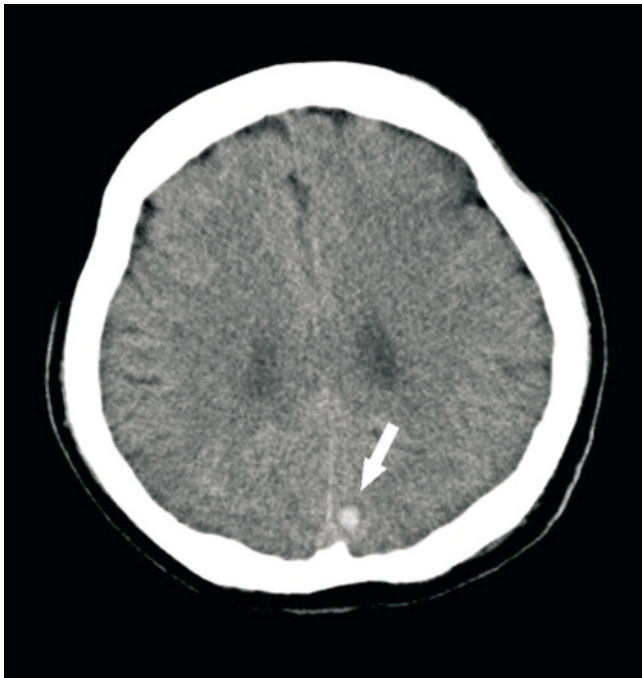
Cranial CT scan revealing a small hyperdense nodular lesion in the left parietal lobe indicating a brain abscess with hemorrhage (the white arrow key).
